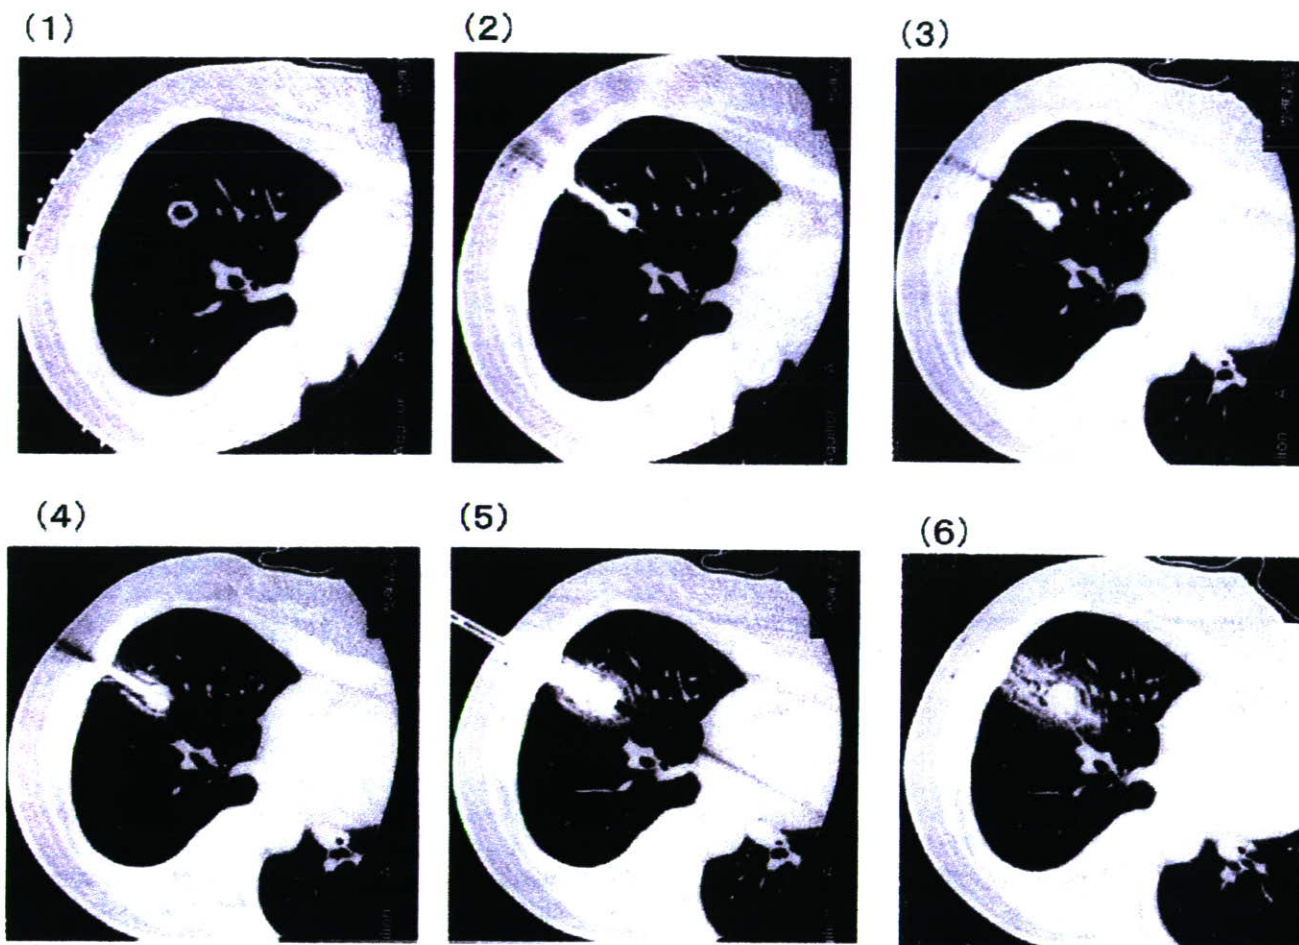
Sequential changes of the pulmonary parenchyma on computed tomographic scanning after freezing and thawing. 1, The metastatic tumor is located in right S4. 2, The cryoprobe penetrates the tumor. 3, Five minutes after the beginning of first freezing, the change of surrounding lung is quite small. 4, After first thawing, consolidation along the cryoprobe can be seen. 5, Five minutes after the beginning of second freezing, extension of the consolidated area can be seen. 6, After third thawing.
